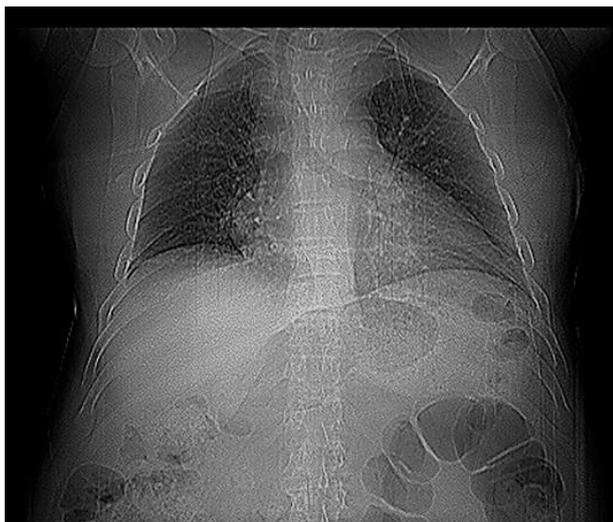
Chest radiography of retrosternal goiter case with upper mediastinal widening
